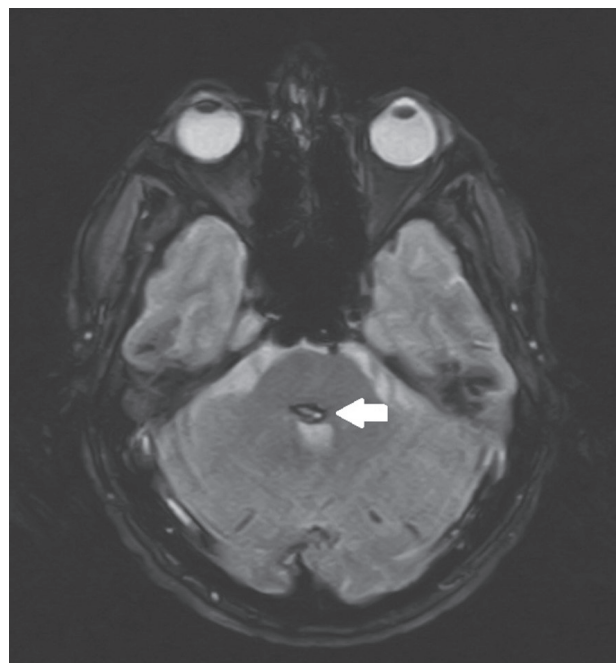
Axial brain magnetic resonance imaging two months after pontine hemorrhage: Susceptibility weighted imaging (SWI) sequence showing a pontine mixed signal intensity core and a hypointense hemosiderin rim (arrow).
